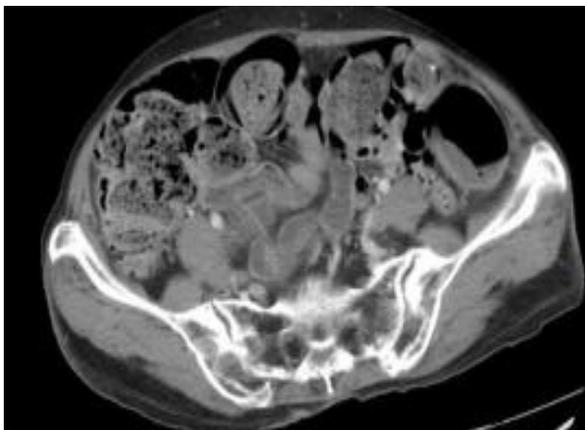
(b) CT- Carcinoma Recto- sigmoid causing intestinal obstruction.
